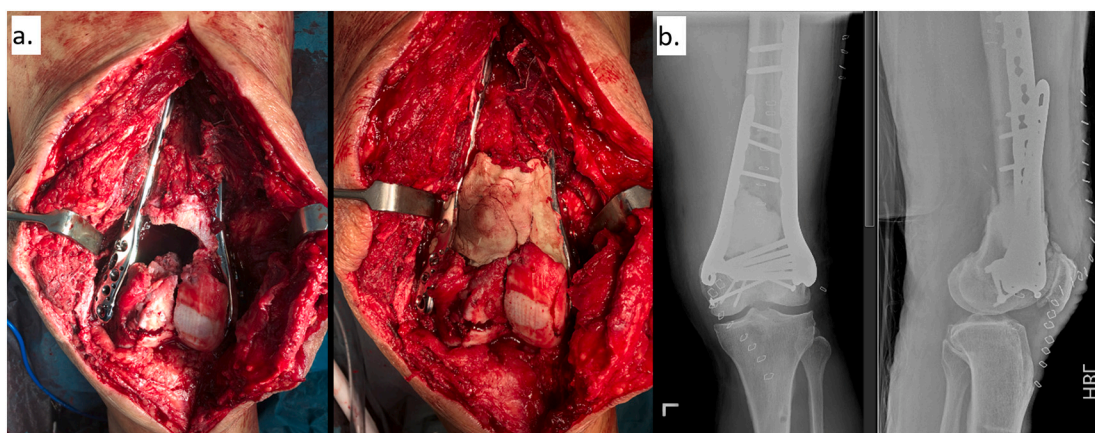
a: Intra-operative photos post fixation with anterior metaphyseal bone defect and addition of cement of Masquetlet stage I. b: Post-operative radiographs after Masquetlet stage I.
